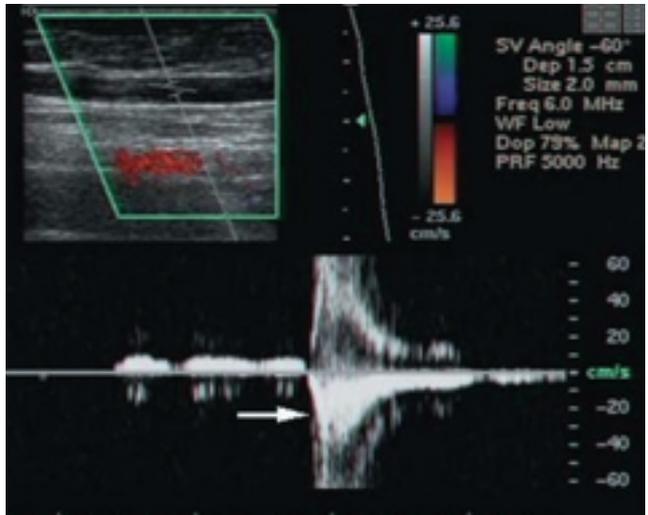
Doppler spectral image shows reflux waveform (arrow) in the right greater saphenous vein during the Valsalva maneuver.
